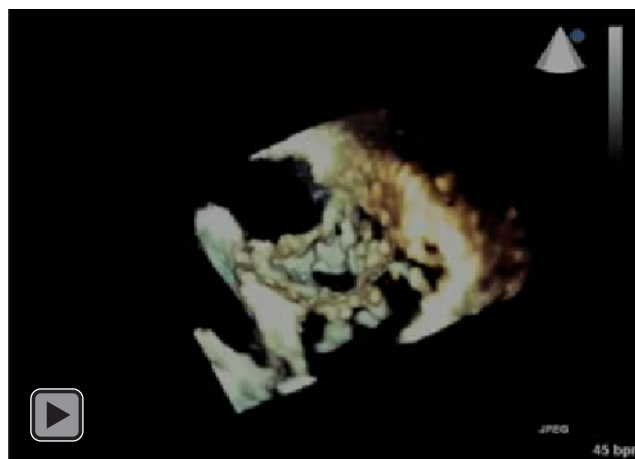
(A) Live 3D TTE. 'En face' view of the tricuspid valve showing a hole in the anterior leaflet responsible for severe regurgitation. (B) Surgical view after a right atriotomy. AL: anterior leaflet of the tricuspid valve; PL: posterior leaflet of the tricuspid valve; SL: septal leaflet of the tricuspid valve; TTE: transthoracic echocardiography; TH: tricuspid hole. Asterisks delimited the TH.
